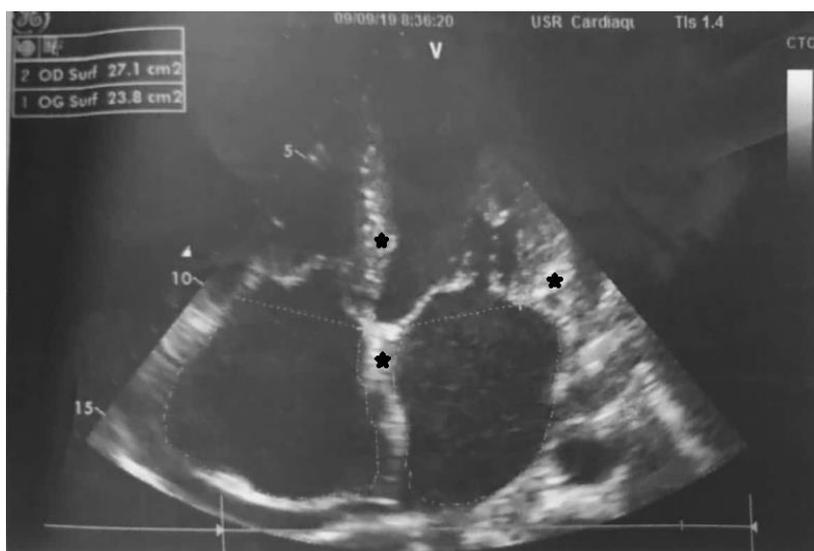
Transthoracic echocardiography showing a non-dilated and, hypertrophied left ventricle of 12mm with preserved systolic function, a dilated, hypertrophied right ventricle with preserved systolic function, pulmonary hypertension and dilated inferior vena cava
